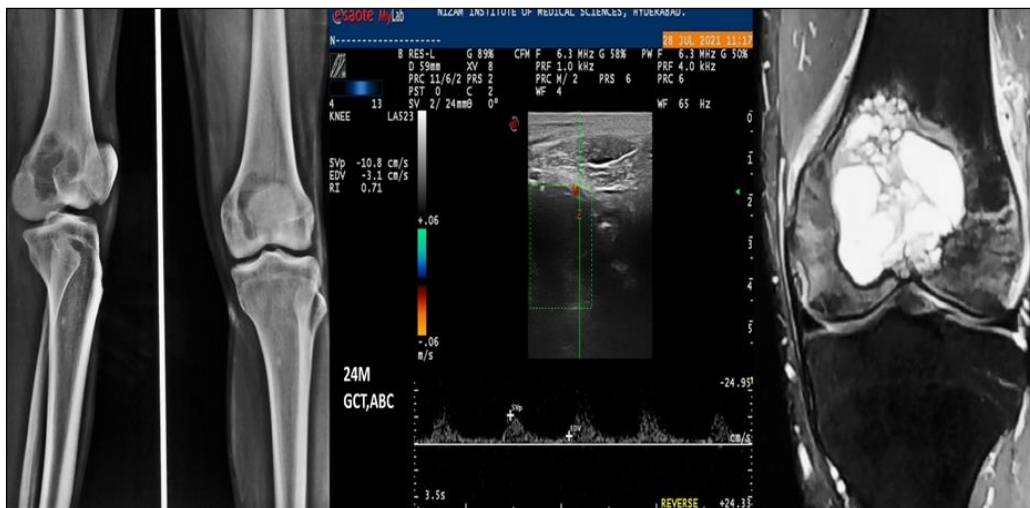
Well defined lytic lesion with sclerotic rim in epimetaphysis of lower end of femur (Grade I). Lesion is having ABC component, clearly depicted as fluid- fluid level in STIR MRI. On colour doppler USG lesion is showing high RI
